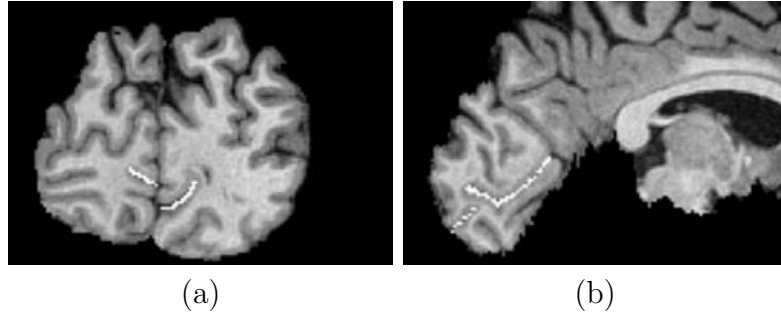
The pointset of Calcarine Sulcus shown in MRI of NA1. The White line here is refer to Calcarine Sulcus.(a) cornal. (b) sagital.
